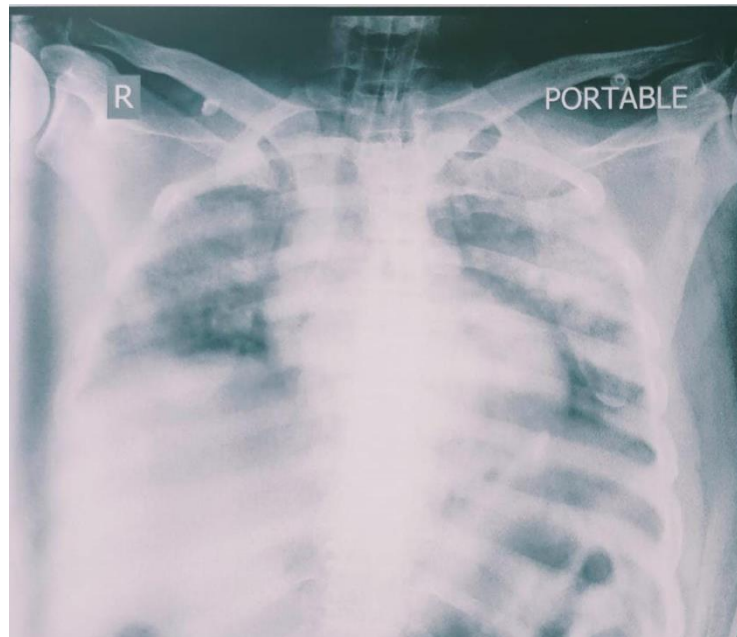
Immediate post op chest x-ray
